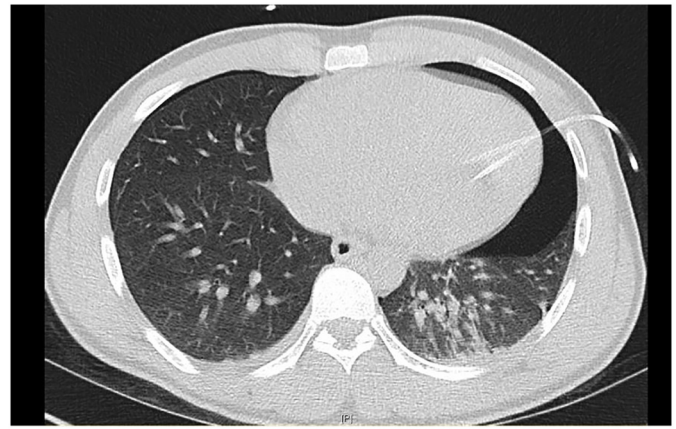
CT scan demonstrating left ventricular location of catheter, pneumothorax and lack of pericardial effusion.
